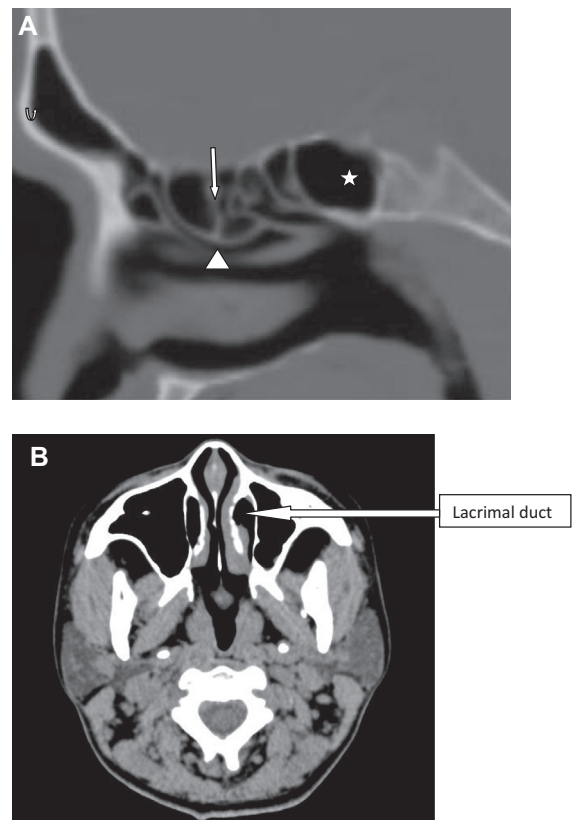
(A) Sagittal CT image of the paranasal sinus shows frontal sinus (curved up arrow), frontal recess (arrow head), ethmoidal sinus (arrow) and sphenoidal sinus (star).
